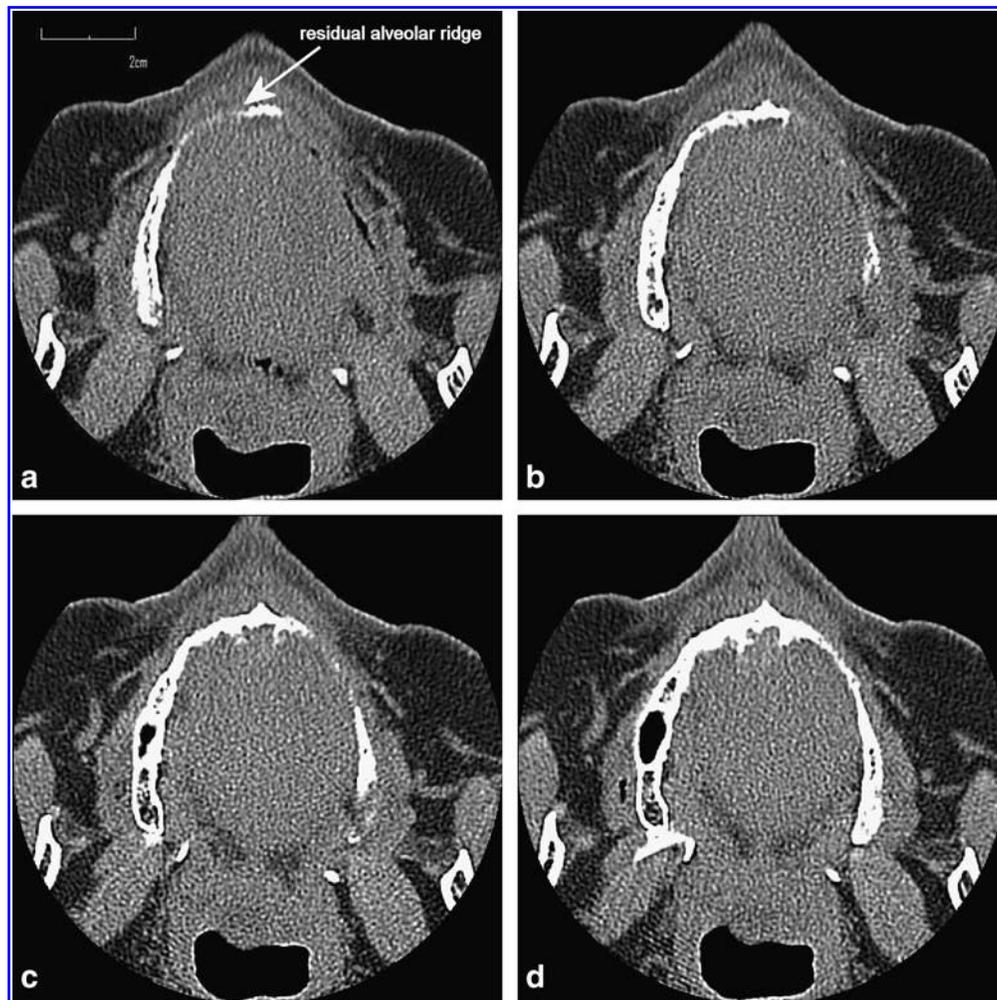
(a-d) Preoperative CT with minimal residual bone in the maxilla (caudal to cranial levels).
